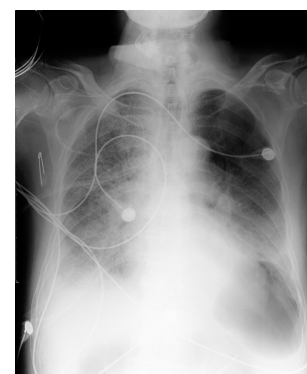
Chest X-ray on the day of admission to Shanghai Public Health Clinical Center (April 19, 2013): inflammation in both lungs.
